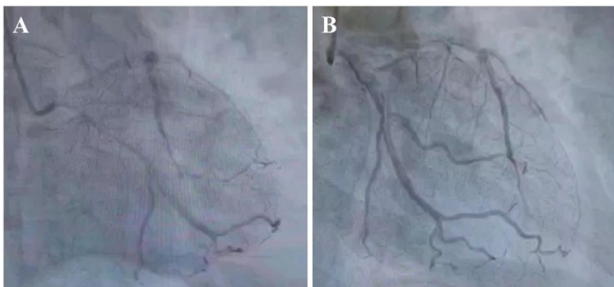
Representative CT images of patients of a patient (A) before and (B) after bypass surgery.
